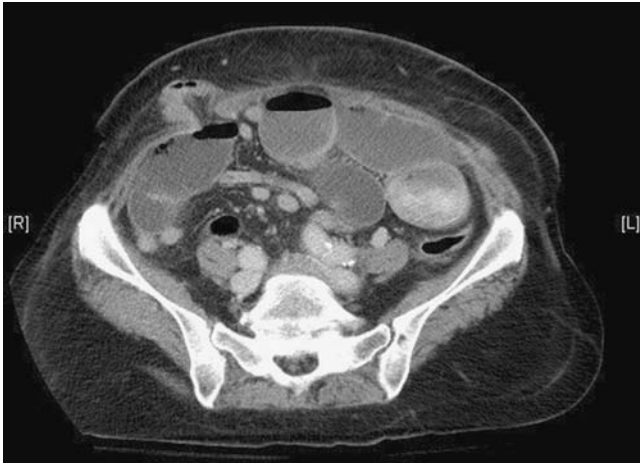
Axial computed tomography (CT) scan showing an incarcerated obstructing trocar site hernia, with dilated proximal loops containing oral contrast and decompressed distal small bowel loops.
